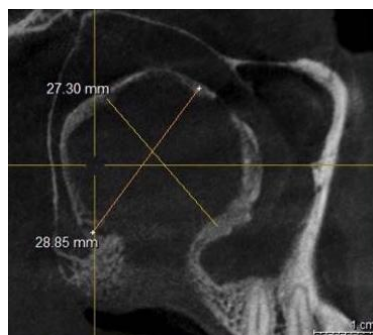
Three months post-operative CBCT
